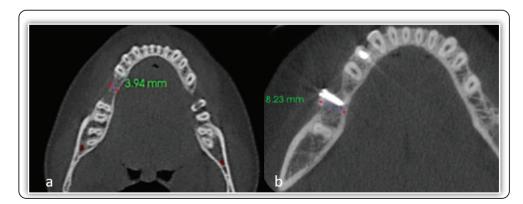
Axial Cut of The CBCT Showing Increase in Alveolar Ridge Width after Six Months (~ 8 mm) (A) in comparison to the pre-operative width (~ 4 mm) (B)
